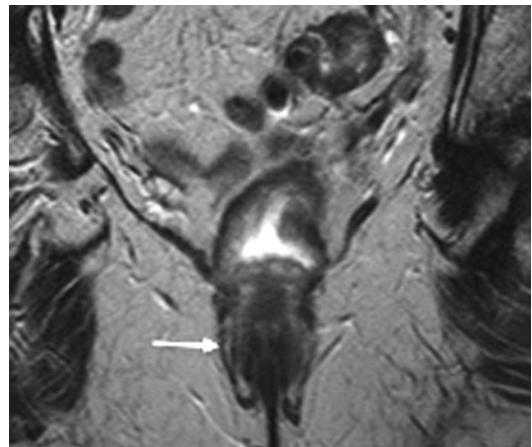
Coronal T2-weighted fast spin-echo MRI image of the anus: note atrophy of the external anal sphincter (*thin arrow*)
